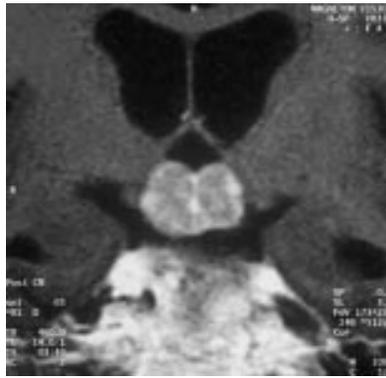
T1 weighted coronal MR image showing a circumscribed hypothalamic tumour.
